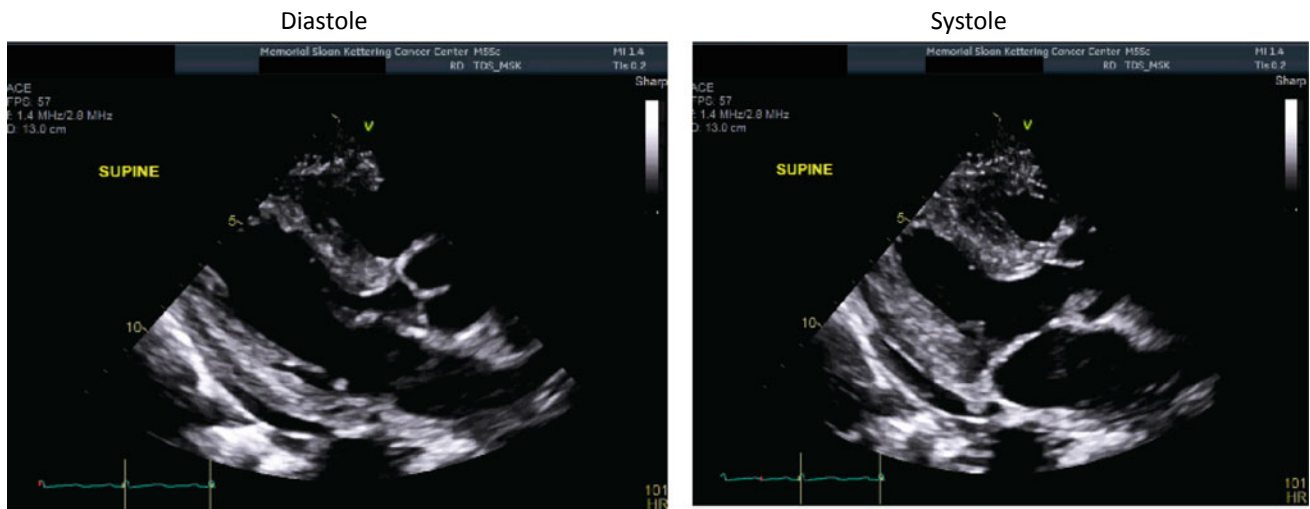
Echocardiographic images in diastole and systole prior to CAR T-cell treatment showing normal systolic function
